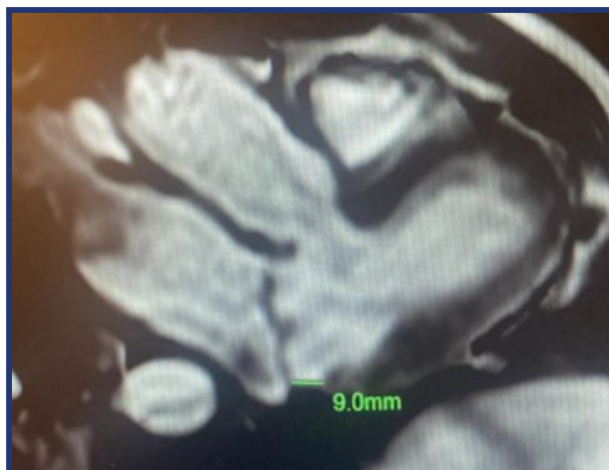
Echocardiogram showing atrial displacement of the mitral annulus plane.
